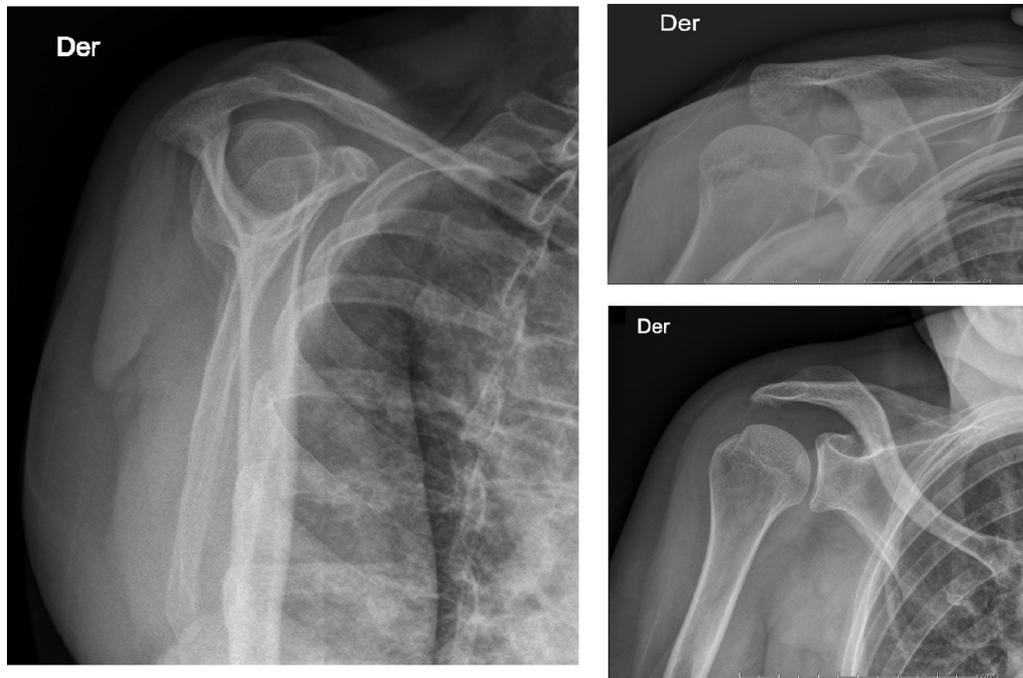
Right shoulder x-ray projections performed after closed reduction confirmed appropriate joint reduction.
